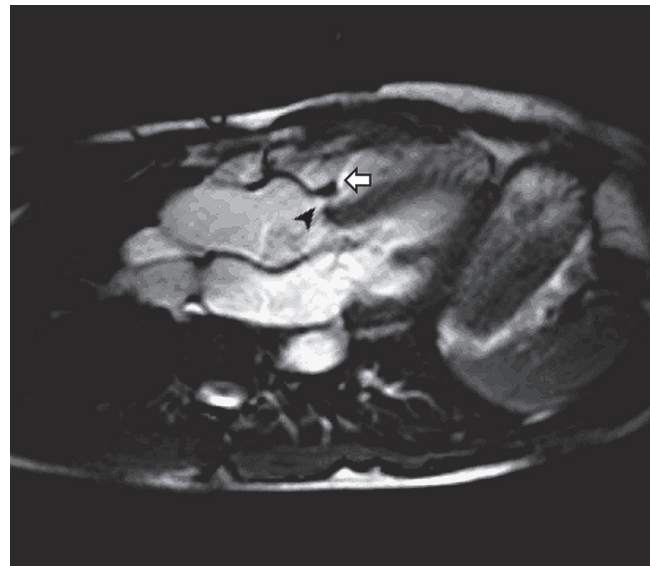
■ Sinus of Valsalva aneurysm. Steady-state free-precession cine cardiovascular magnetic resonance image of a ruptured sinus of Valsalva aneurysm (arrowhead) with signal void (arrow) in the right ventricle from associated turbulent flow.
